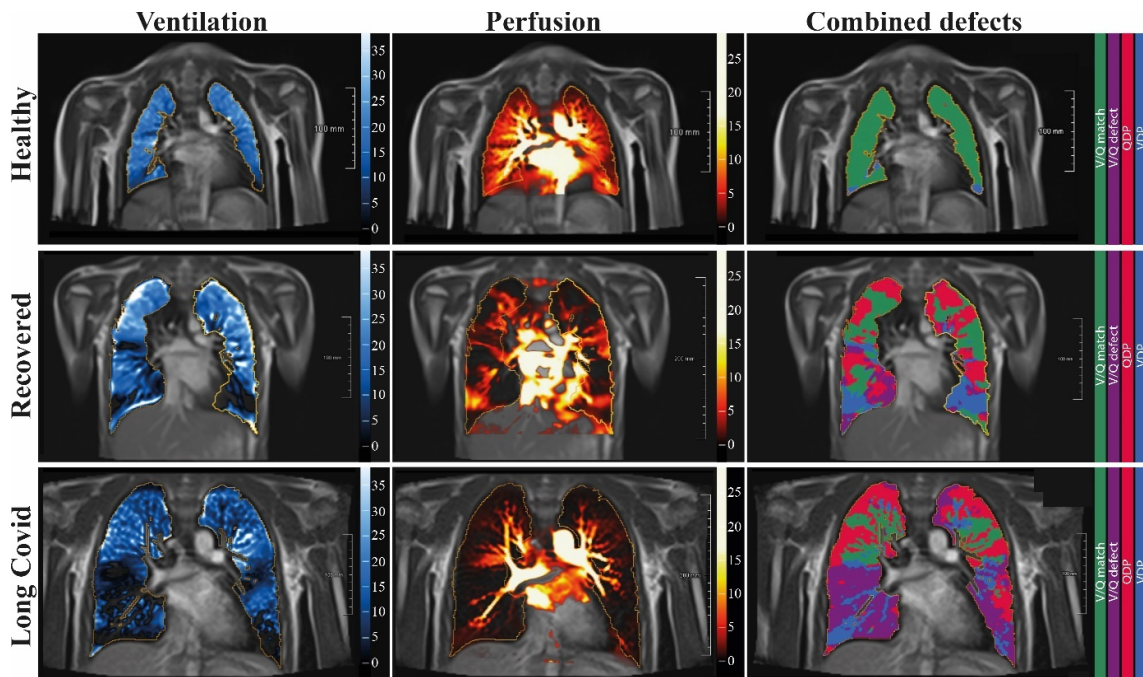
Free-breathing phase-resolved functional lung (PREFUL) low-field MRI at 0.55T with calculated parameters at an axial plane after automatic registration to a mid-expiration position and lung parenchyma segmentation. From left to right, representative color-coded images of functional show ventilation defects (VDP, blue), perfusion defects (QDP, red), ventilation/perfusion (V/Q match, green), ventilation/perfusion defects (V/Q defect, purple) in a healthy control (upper row, 7-year-old male), a participant recovered from COVID-19 (middle row, 10-year-old male) and a participant with long COVID (15-year-old male).
